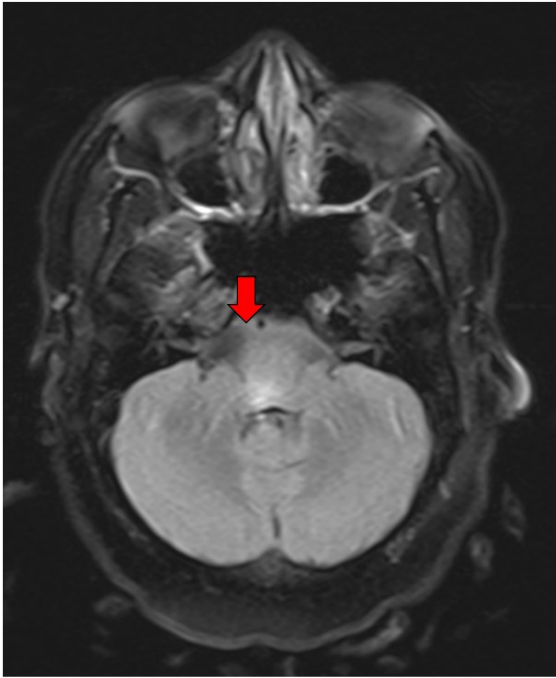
Area-Postrema lesion at floor of 4th ventricle on FLAIR sequence in axial plane
